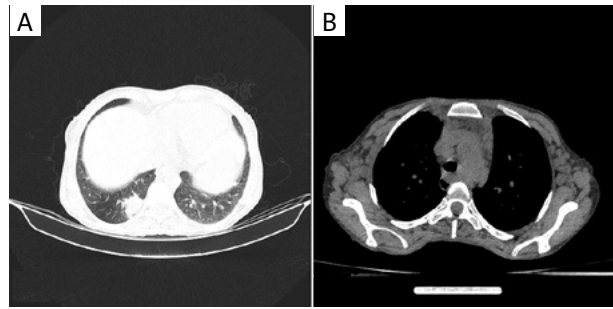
Chest CT scan of the patient. Parenchymal (A) view of chest CT scan with alveolar opacity in the lower lobe of the right lung. Mediastinal (B) view with multiple lymph nodes in the mediastinum
